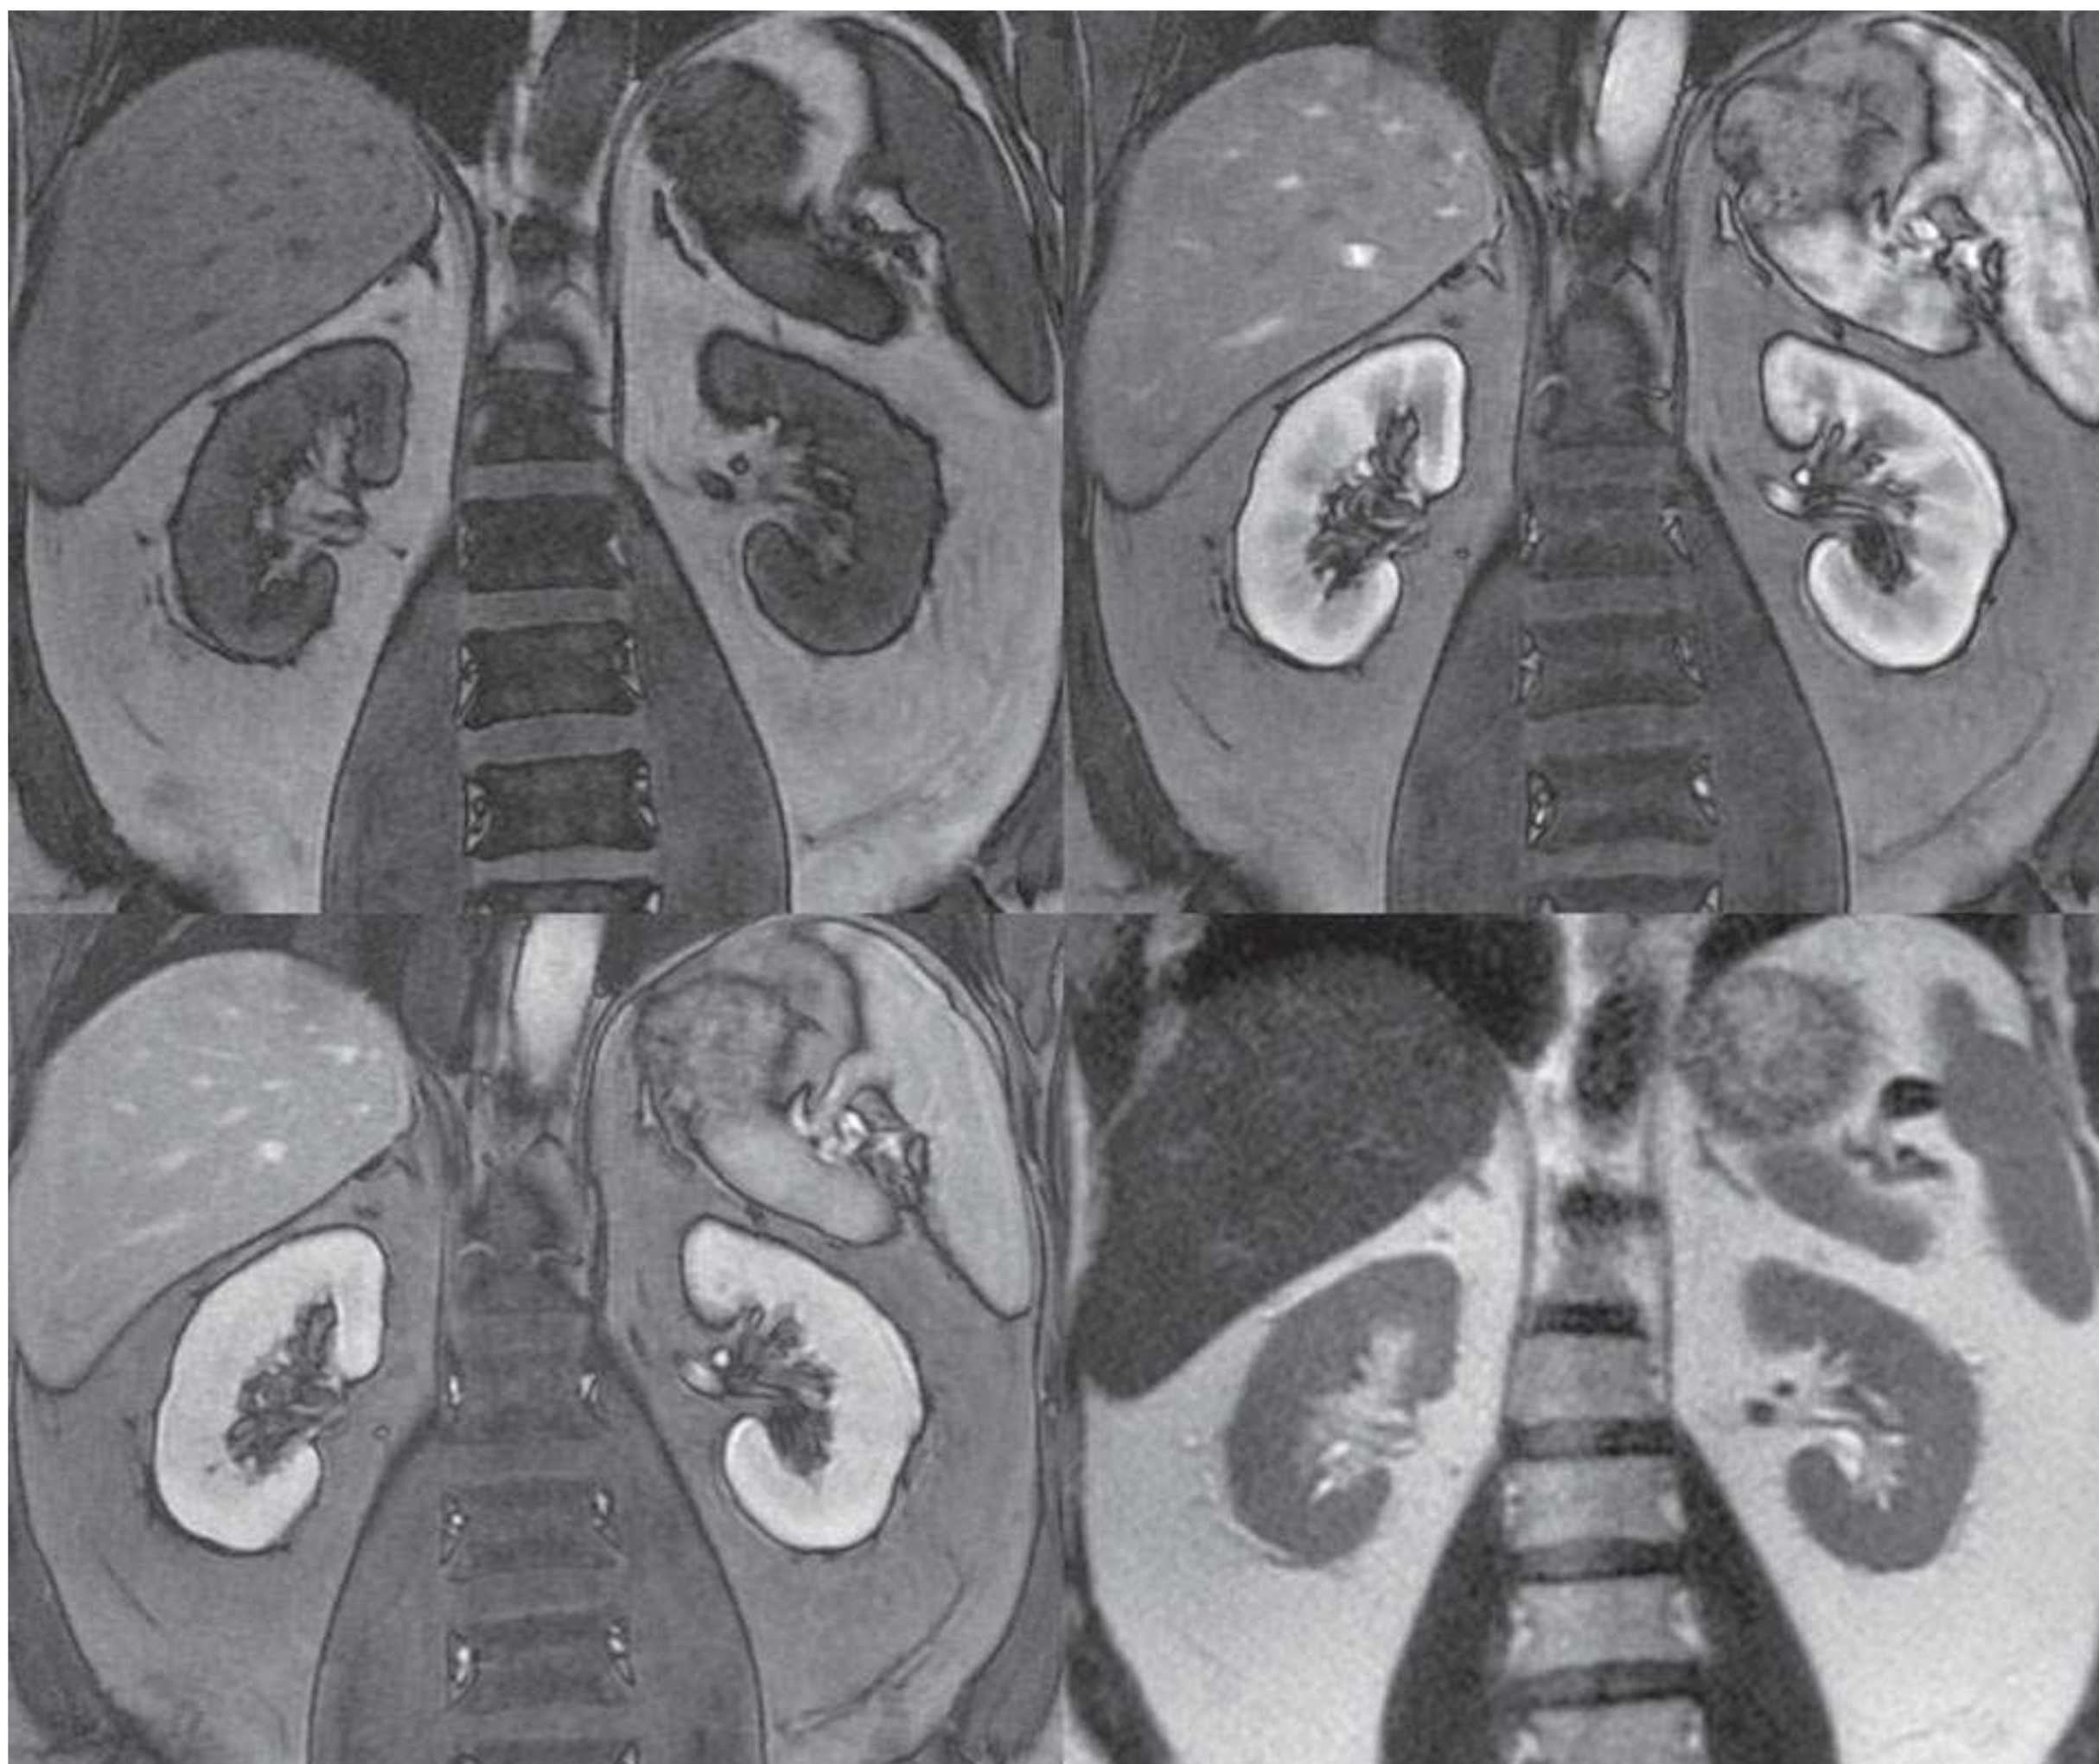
MR images of normal kidneys: T1-weighted without intravenous contrast (*left upper*), contrast-enhanced T1-weighted at corticomedullary phase (*right upper*), contrast-enhanced T1-weighted at nephrographic phase (*left lower*), and T2-weighted (*right lower*).
